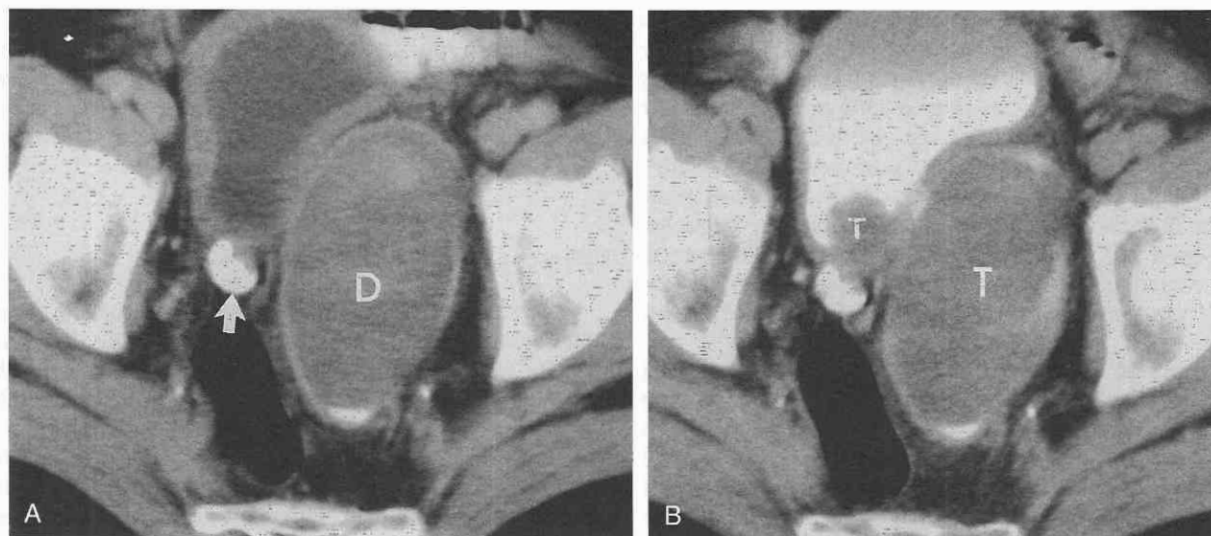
Bladder cancer in a diverticulum. CT scan through a thick-walled and trabeculated bladder with multiple diverticula. A, Early-phase image shows a calculus in the right-sided diverticulum (*arrow*) but possibly a tumor in the left-sided diverticulum (D). B, Delayed excretory-phase image shows tumor (T) both filling the diverticulum and intravesically at the same level.
